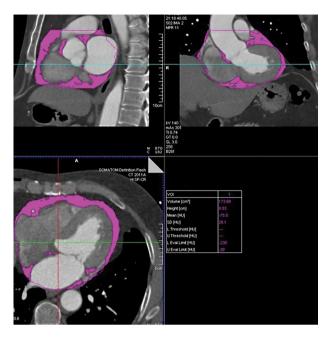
Computed tomography slice shows how the total epicardial adipose tissue volume was measured in sagittal, coronal, and axial views, and the table shows the numeric values
